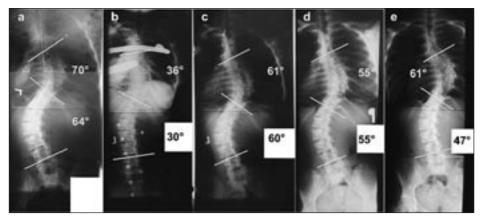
Fig. 8a) – X-ray picture of spine before application of Chêneau brace, age over 16 years, Thoracic curve = 70° dx, lumbar curve = 64° sin. Fig. 8b) – the spine in Chêneau brace, Th = 36° dx, L = 30° sin. Fig. 8c) – over 1 year after conservative treatment of Chêneau brace, Th = 61° dx, L = 60° sin. Fig. 8d) – 24 hours after removal of the brace; age 18 years, Th = 55° dx, L = 55° sin. Fig. 8e) – the spine in age 26 years, Th = 61° dx, L = 47° sin.
